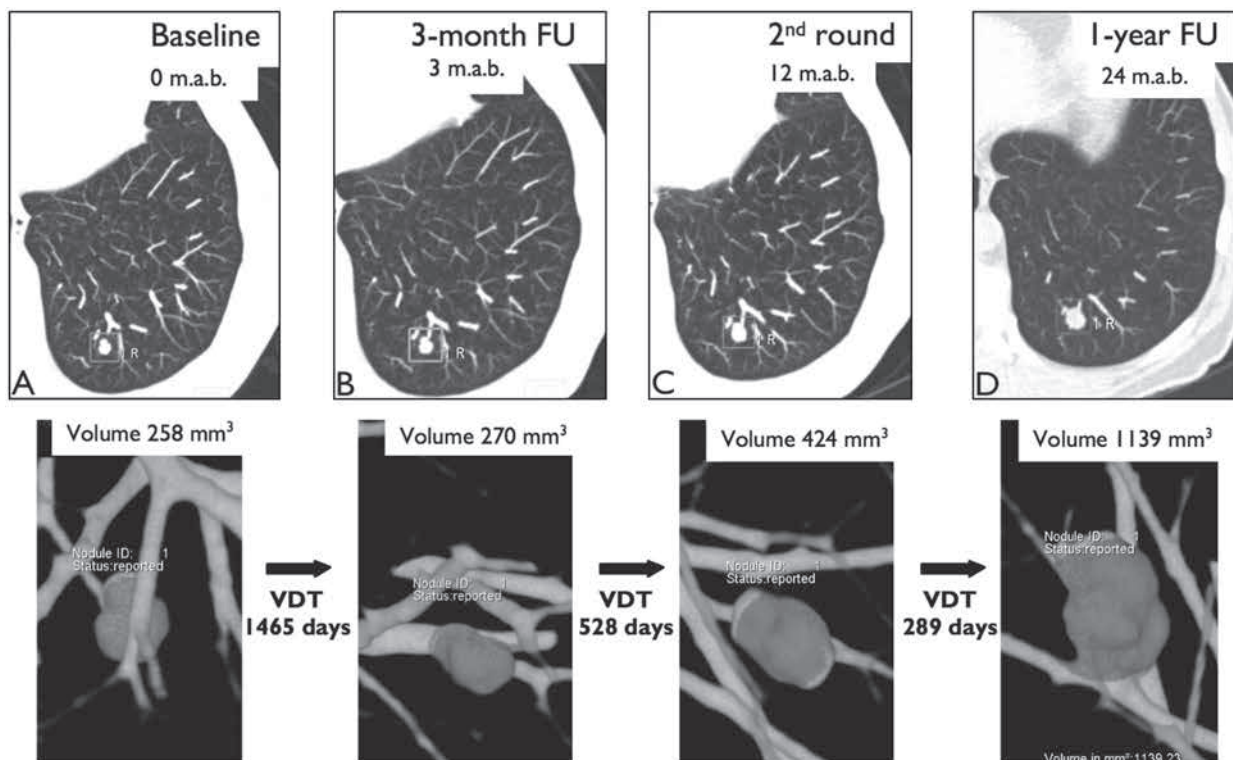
Growing malignant lesion in a 65-year-old man. Axial computed tomography (CT) scan (A) shows a nodule (arrow) with a volume of 259 mm^3 in the left lower lobe. Three months later (B), the nodule volume increased to 270 mm^3 (volume-doubling time [VDT] = 1468 days). One year after baseline CT (C), the nodule volume was 425 mm^3 (VDT = 528 days). 28 months after baseline CT (D), the nodule volume was 1132 mm^3 . The VDT at that time was 289 days. Lobectomy revealed a stage IA adenocarcinoma. M.a.b. = months after baseline.
